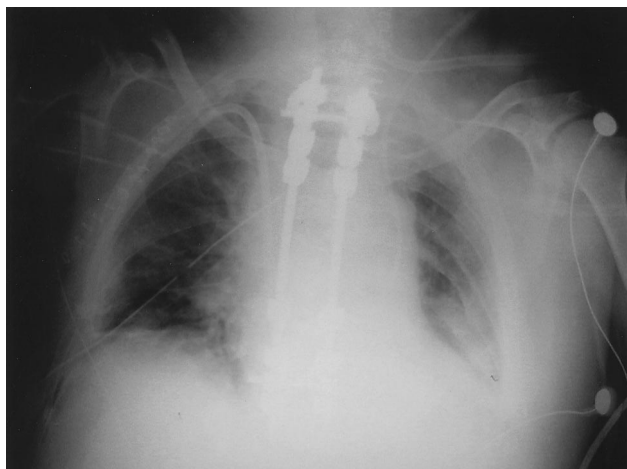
Preoperative chest radiograph.
